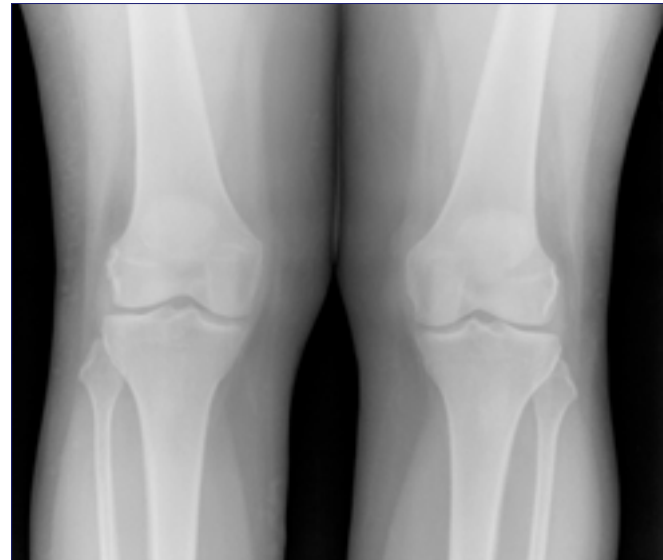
Plain radiograph of normal knees.
